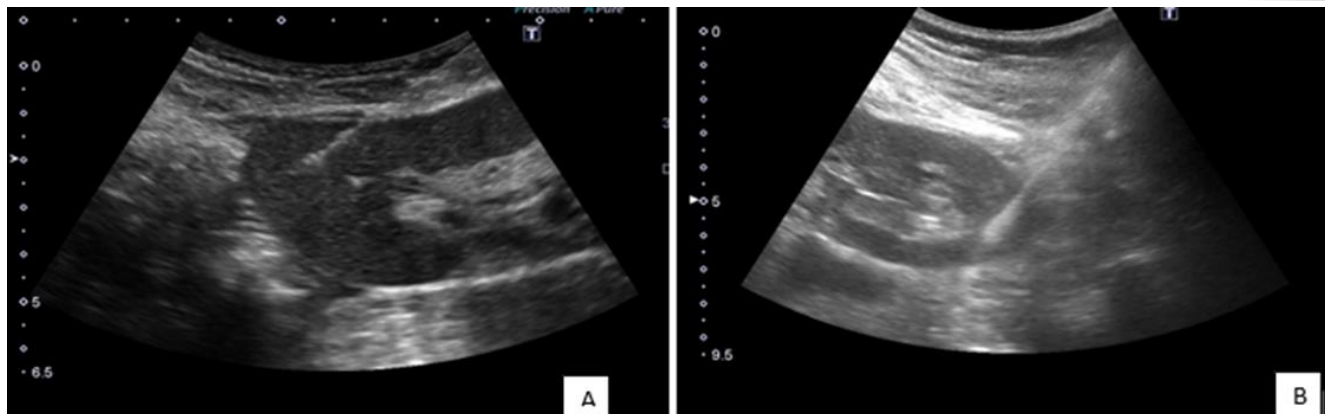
Transplant and native renal biopsy. (A) Transplant kidney ultrasound (longitudinal view) with biopsy needle in upper pole cortex via caudo-cranial approach. (B) Native kidney ultrasound (longitudinal view) with biopsy needle in lower pole cortex
